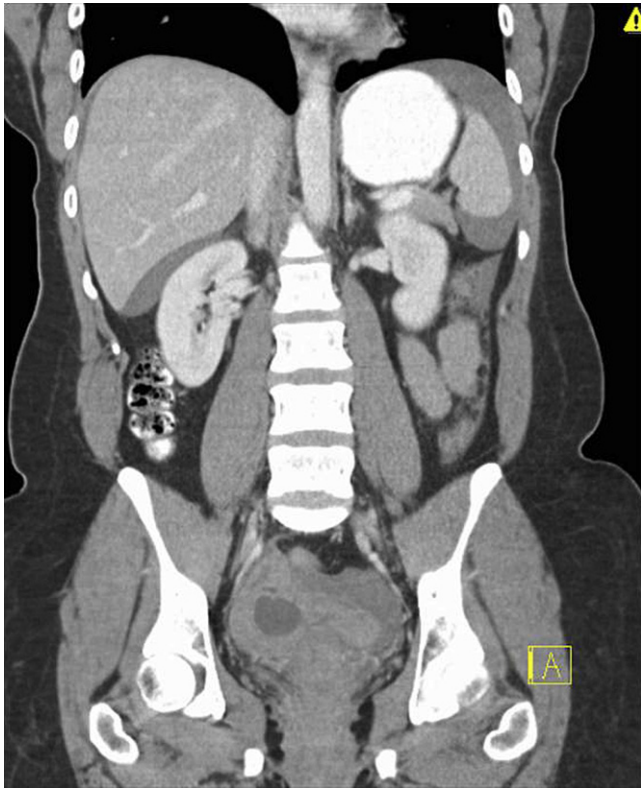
A 35-year-old patient with left-sided abdominal pain and nausea. Coronal contrast-enhanced computed tomography, showing a 2.5-cm homogeneous hypodense cyst in the right ovary and a moderate amount of hemoperitoneum (which is densest in the pelvis), which represents a ruptured ovarian cyst with associated hemorrhage. Active hemorrhage was not identified, and the patient was treated conservatively.
